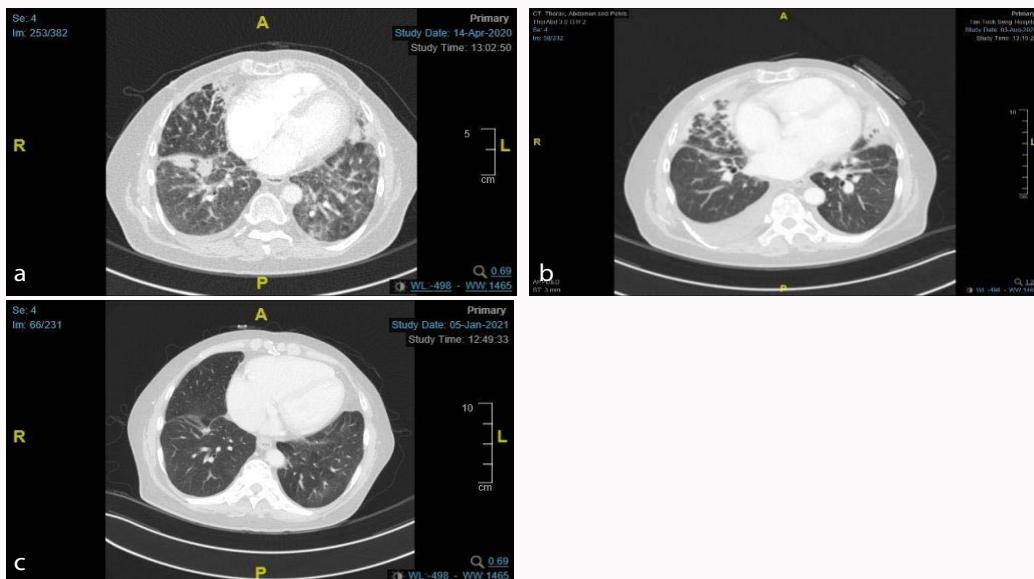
(Clockwise, starting from left a) CT Pulmonary angiogram showing lymphangitis in April 2020, b) CT scan post 2 cycles of CAPOX, c) CT thorax done in Jan 2021 after initiation of alectinib.
